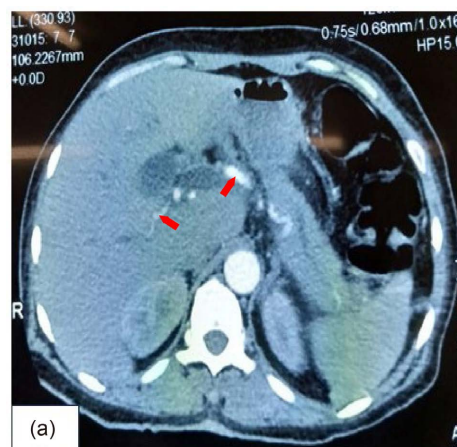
Injected abdominal computed tomography showing dilation of the intra- and extra-hepatic bile ducts (patient number 1).
